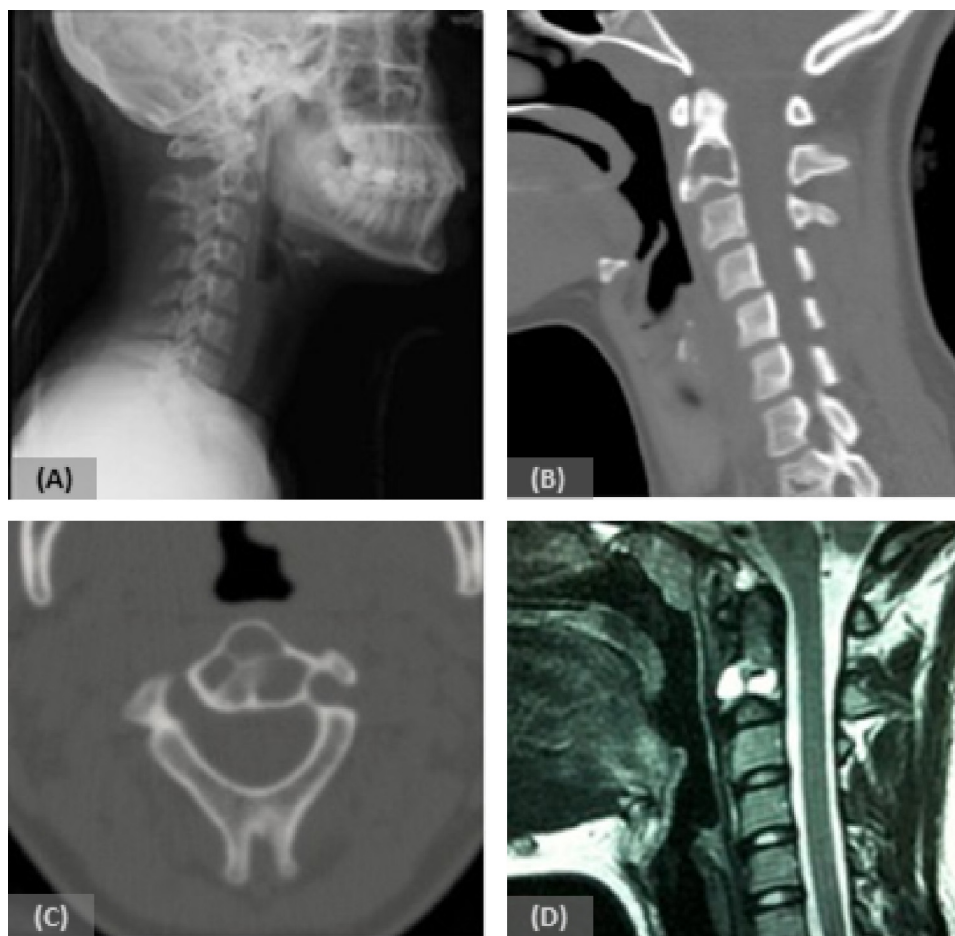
Preoperative images: (A) Plain radiography showing a lytic lesion at the C2 body. (B, C) Sagittal and axial computed tomography (CT) scans demonstrating an expansile osteolytic lesion. Note the integrity of the thin cortical boundaries and multiple partitions in its interior. (D) Preoperative T2 weighted image (T2WI) magnetic resonance imaging (MRI) showing blood content inside the lesion.
